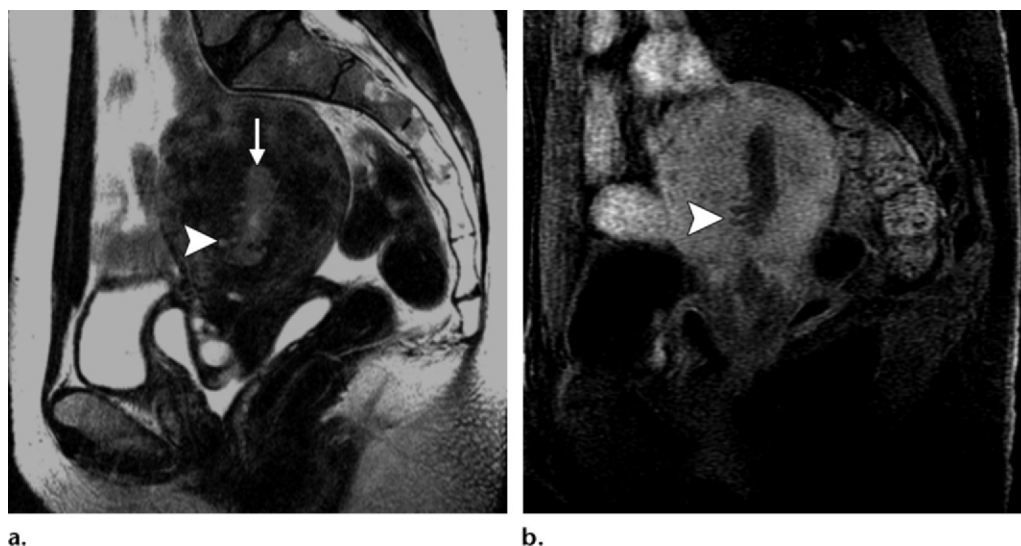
Adenomyosis in a patient with myometrial invasion. (a) Sagittal high-resolution T2-weighted FRFSE MR image shows widening of the junctional zone, small punctate foci of hyperintensity, and striations in the anterior myometrium, findings indicative of adenomyosis (arrowhead). A tumor is also seen in the endometrial cavity (arrow). (b) Sagittal contrast-enhanced T1-weighted 3D MR image shows defects in the anterior myometrium (arrowhead) that correspond to the findings of adenomyosis on the sagittal T2-weighted image. In this case, the signal intensity on the T2-weighted image and the sharply margined appearance on the contrast-enhanced image suggest the presence of adenomyosis in the anterior inner myometrium rather than tumor infiltration, but tumor infiltration cannot be excluded with certainty. The presence of adenomyosis limits the ability to accurately assess myometrial invasion at either sequence.
